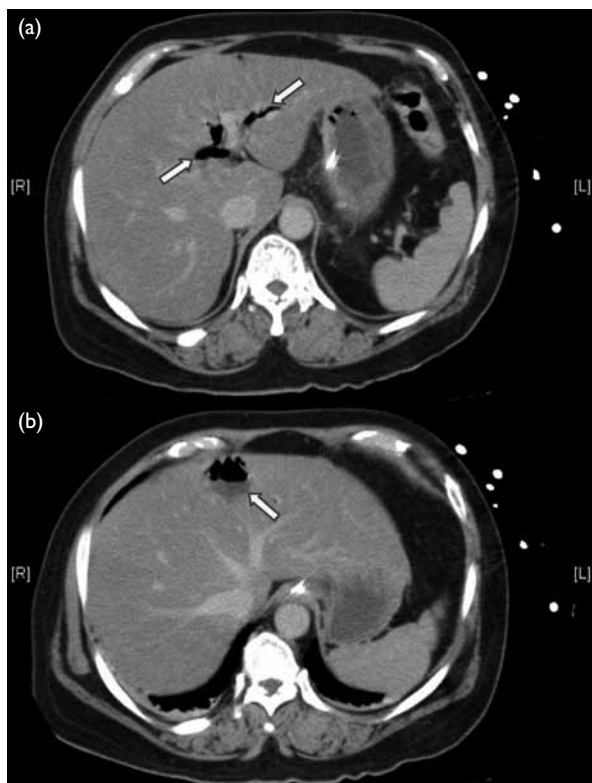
Computed tomographic images showing (a) pneumobilia (arrows), and (b) gas-forming liver abscess (arrow)
